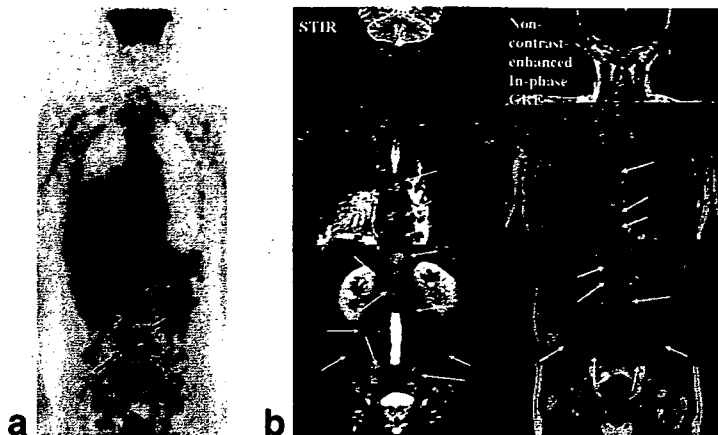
A 70-year-old man with adenocarcinoma and multiple bone metastases. a: FDG-PET shows multiple bone metastases (arrows). b: Whole-body MR also demonstrates the presence of multiple bone metastases as high signal intensities on STIR images (arrows) and low signal intensities on in-phase gradient-echo images (arrows).
